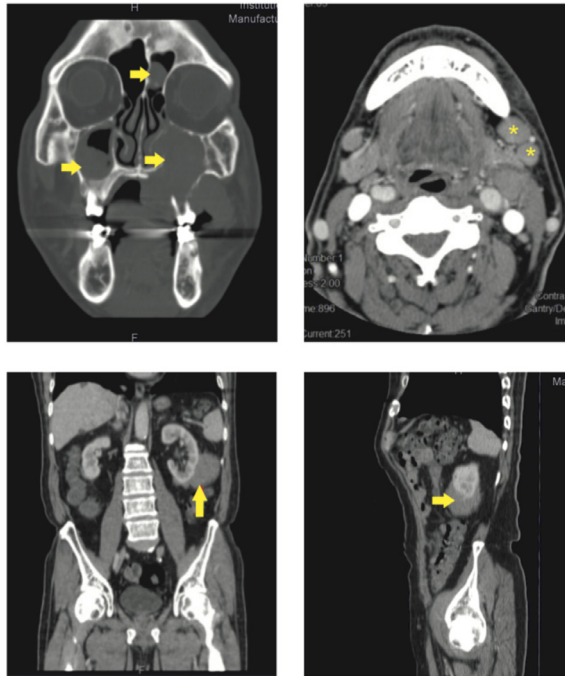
A, Coronal view of computed tomography (CT) maxface. Yellow arrows indicate multiple loci involvement of tumor, including frontal sinus, bilateral maxillary sinus. B, Axial view of CT maxface. Yellow asterisks indicated left submandibular lymphadenopathy. C, Anteroposterior (AP) view of pelvic CT scan. D, Saggital view of pelvic CT scan. Yellow arrows indicate perirenal soft tissue lesion.
